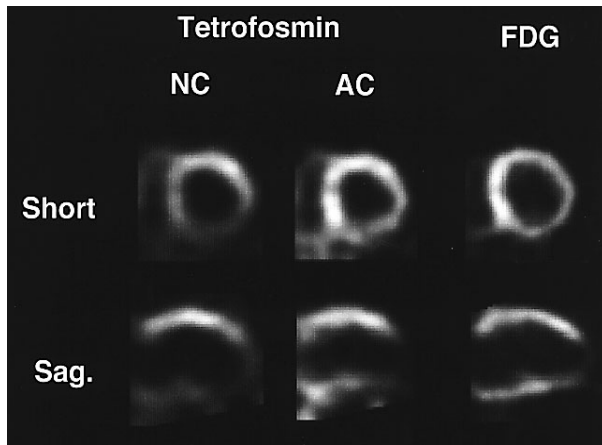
The non-attenuation corrected (NC) ^{99m}Tc -tetrofosmin images (*left*), attenuation corrected (AC) ^{99m}Tc -tetrofosmin images (*center*) and positron emission tomography with ^{18}F -FDG (*right*) from a patient with 3-vessel coronary artery disease. (From Matsunari I, Böning G, Ziegler SI, et al. Attenuation-corrected ^{99m}Tc -tetrofosmin single-photon emission computed tomography in the detection of viable myocardium: comparison with positron emission tomography using ^{18}F -fluorodeoxyglucose. *J Am Coll Cardiol* 1998; 32: 927–935. Reproduced with permission of the American College of Cardiology.)
